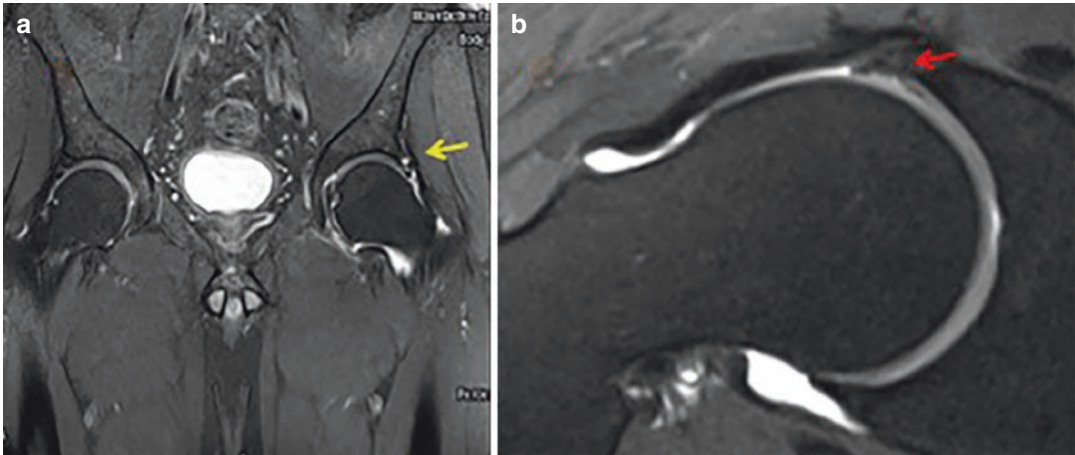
MRI imaging in FAI. (a) MRI paralabral cyst which is indicative of a labral tear (yellow arrow); (b) MRI arthrogram showing an increase in alpha angle and labral degeneration (red arrow)
